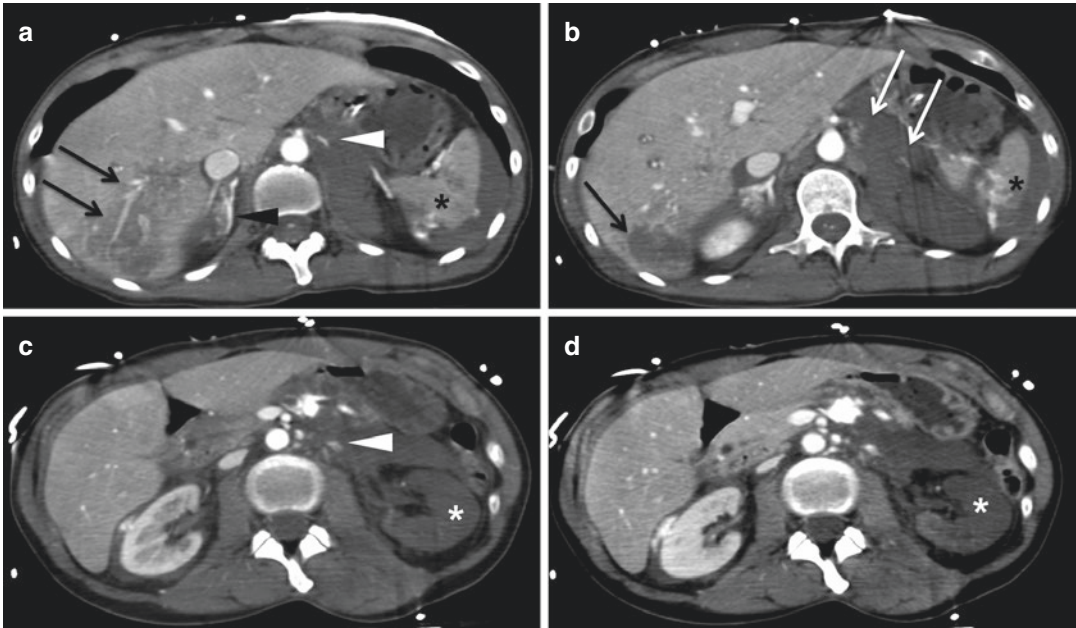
Young girl fallen from great height. (a–d) contrast-enhanced CT scans shows traumatic lesion of the body and the tail of the pancreas (*white arrow*), intraglandular (*white arrowhead*) and extraglandular active bleeding. There are other associated organ injuries: liver (*black*
